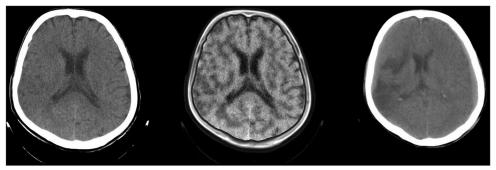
The source (left) and processed (middle) CT images of first hours of stroke onset and the follow up (right) CT images
